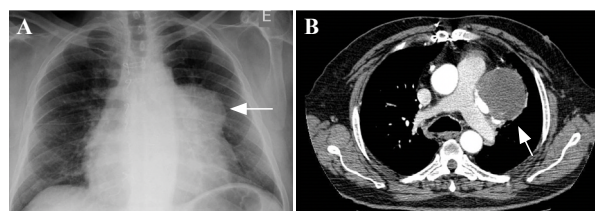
Saphenous vein graft aneurysms (SVGA) incidental finding. A: initial chest X-ray with the incidental finding of a mass (arrow indicated) silhouetting the heart; B: initial computed tomography coronary angiography showing a pseudo-aneurysm (arrow indicated) of the saphenous vein grafts from the aorta to obtuse marginal artery (SVG-OMA) bypass with a maximum diameter of 66 mm and extensive thrombosis, as there is minimal contrast within its lumen.
